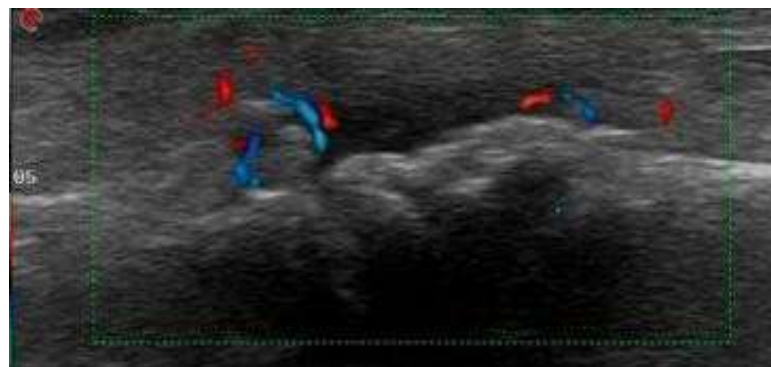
USG grayscale with colour Doppler image of 60 yr old female RA patient showing hypertrophy of synovium at MCP joint
